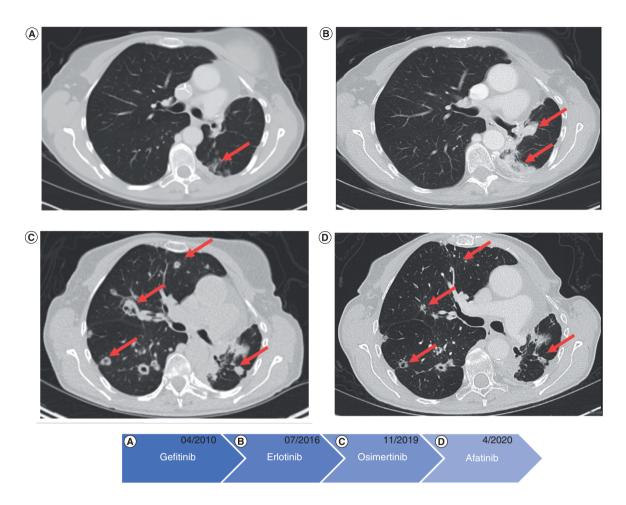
Serial CT scan axial sections at same level showing evolution of cancer captured at the time of progression on treatments. (A) Progression on gefitnib in April 2010. (B) Progression on erlotinib in July 2016. (C) Progression on osimertinib in November 2019. (D) Response on afatinib in April 2020.
